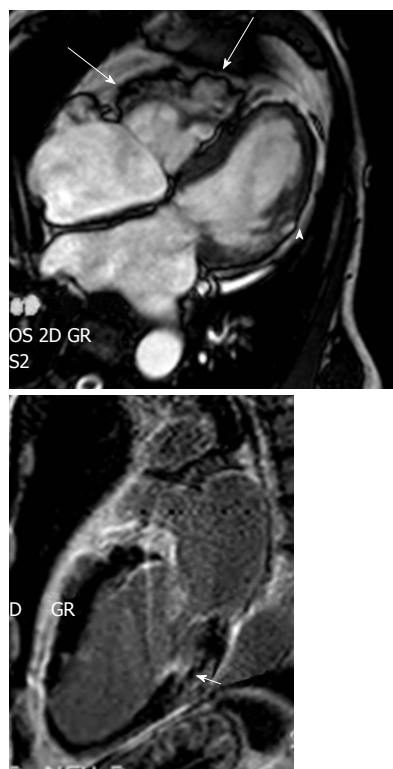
Regional right ventricular dyskinesia of the right free wall detected by cardiac imaging are considered as a major criterion for right ventricular cardiomyopathy/dysplasia according to the revised task force criteria if additionally right ventricle dilation or impaired right ventricle ejection fraction are present. These cardiac magnetic resonance images (upper panel 4-chamber view, lower panel 2-chamber view late sequences) show aneurysms of the RV free wall (long arrows), and LV involvement detected by a small akinetic region (arrowhead) and late gadolinium enhancement of the posterior LV wall (short arrow), confirming biventricular involvement. ARVC/D: arrhythmogenic right ventricular cardiomyopathy/dysplasia; RV: Right ventricle; LV: Left ventricle.
